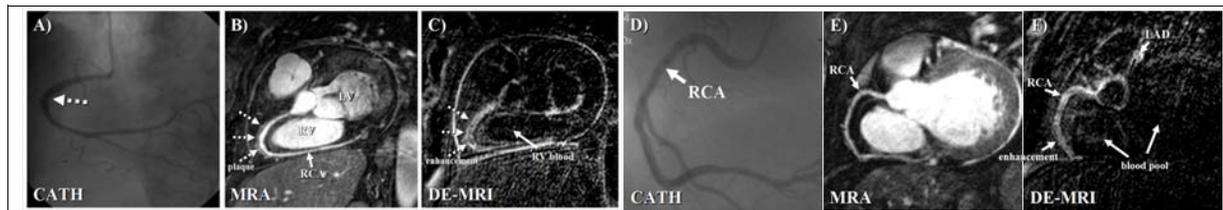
Two patients with luminal irregularities on x-ray angiogram (A, D). B) Corresponding contrast enhanced coronary MRAs showing an irregular lumen (B, E). In (B), an iso-intense layer suggestive for outward remodeling can be observed. C, E) Delayed enhancement (~60minutes post Gd) vessel wall images demonstrate contrast uptake in the proximal and mid RCA suggestive for diffuse atherosclerosis.
